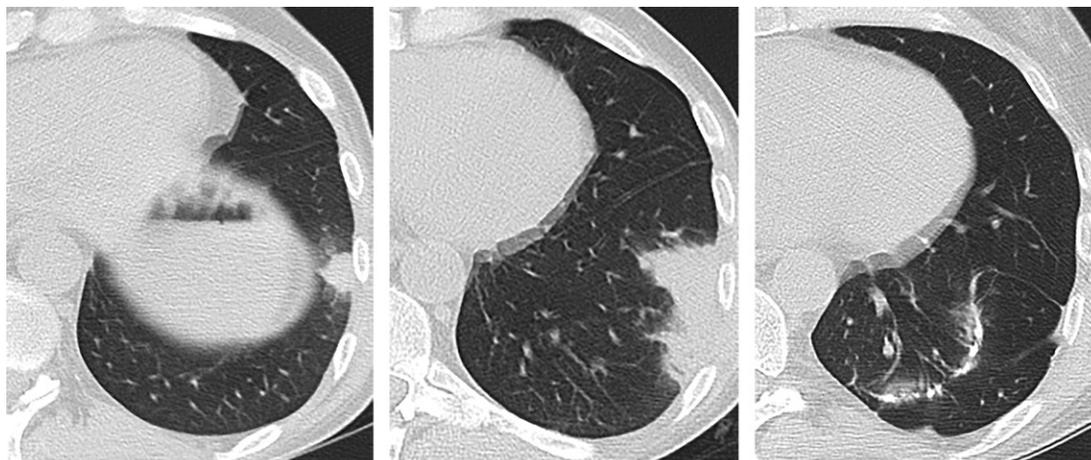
Surgical treatment of PM in a 51-year-old man with renal and stem cell transplants complicated by graft-versus-host disease. (a) Axial CT image of the left lower lobe shows a nodule with mild surrounding ground-glass opacity. (b) Axial CT image obtained 1 month later depicts an enlarged nodule. (c) Axial CT image obtained at follow-up 5 months after surgery shows complete resolution with no recurrence.
